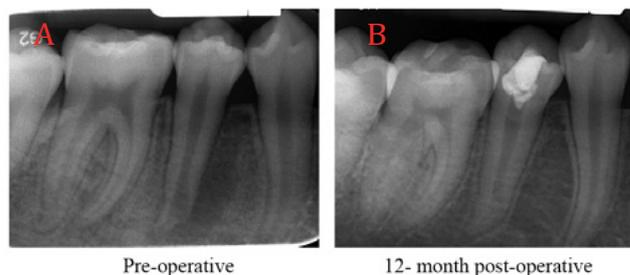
(A) Preoperative radiograph of tooth #29. (B) One year follow up after regenerative endodontic treatment (Courtesy: Dr. Avina Paranjpe, Seattle, WA)
